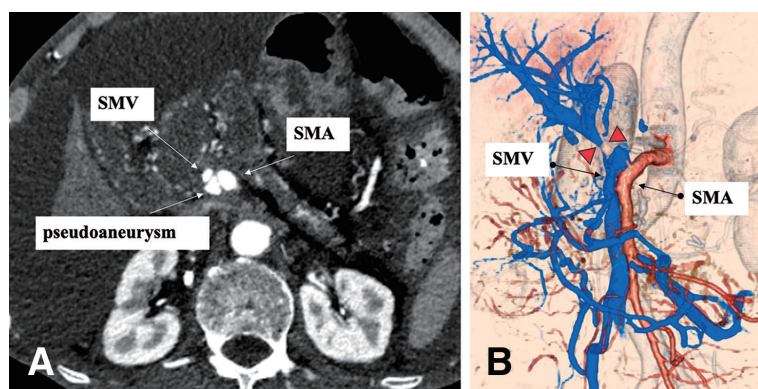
(A) Axial E-CT reveals early enhancement of the SMV, showing the abnormal connection between the SMA and the SMV via a pseudoaneurysm. (B) E-CT with 3-dimensional reconstruction displays a fistula between a SMA and SMV in the proximal SMA with H-type communication, accompanied by stenotic changes in the portal vein proximal to the communication site (arrowheads). E-CT: enhanced computed tomography; SMV: superior mesenteric vein; SMA: superior mesenteric artery
